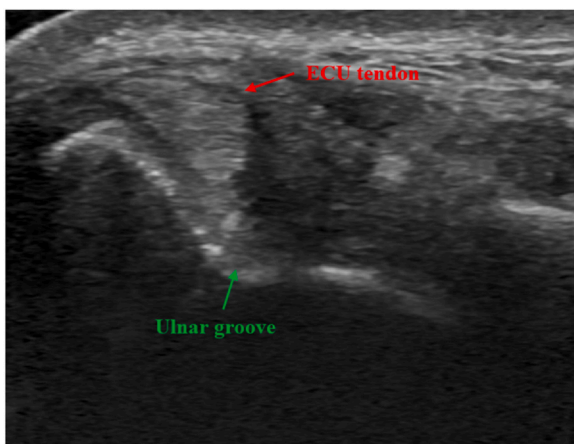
Ultrasound showing subluxation of the ECU tendon out of the ulnar groove during forearm supination.
